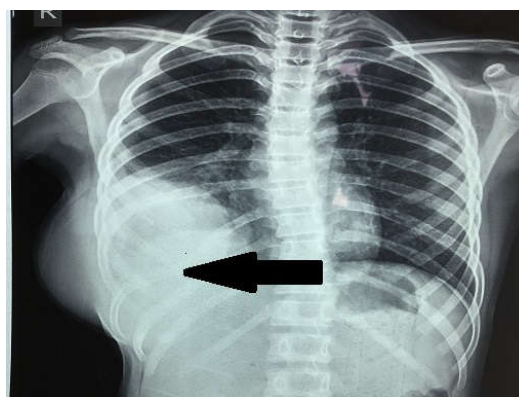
Chest X-ray of the patient revealed an opacity in the right lower zone (marked with arrow)
